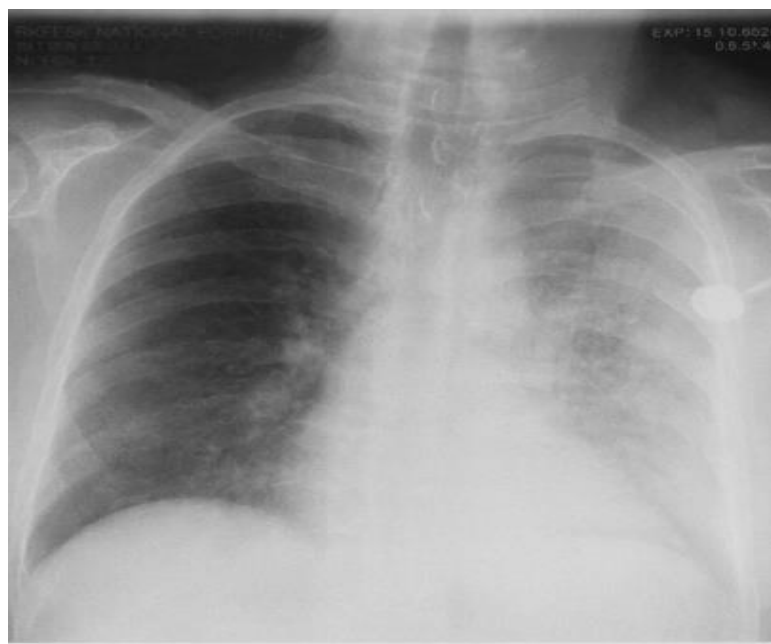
Post Intervention Chest Xray
